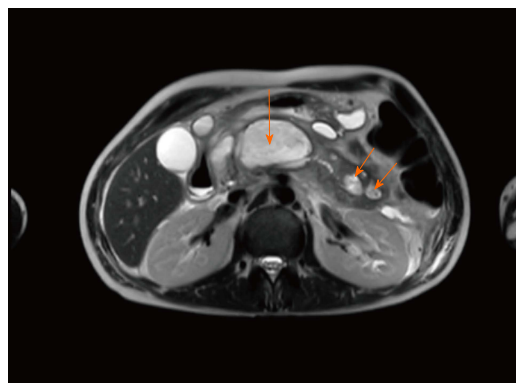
Magnetic resonance imaging of abdomen with and without contrast during July 2016 presentation. Image displays large walled-off necrosis within the body and tail of the pancreas (arrows).
